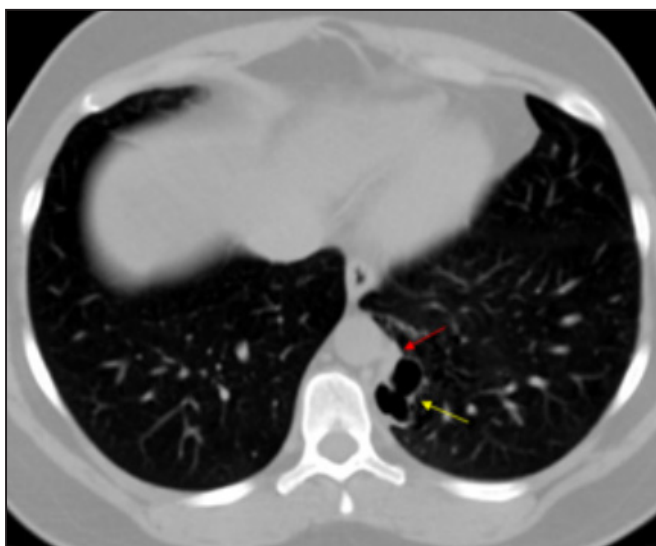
Bronchogenic sequestration. Unenhanced CT image demonstrating a thin-walled septate cystic lesion (yellow arrow) with a feeding systemic vessel (red arrow).
